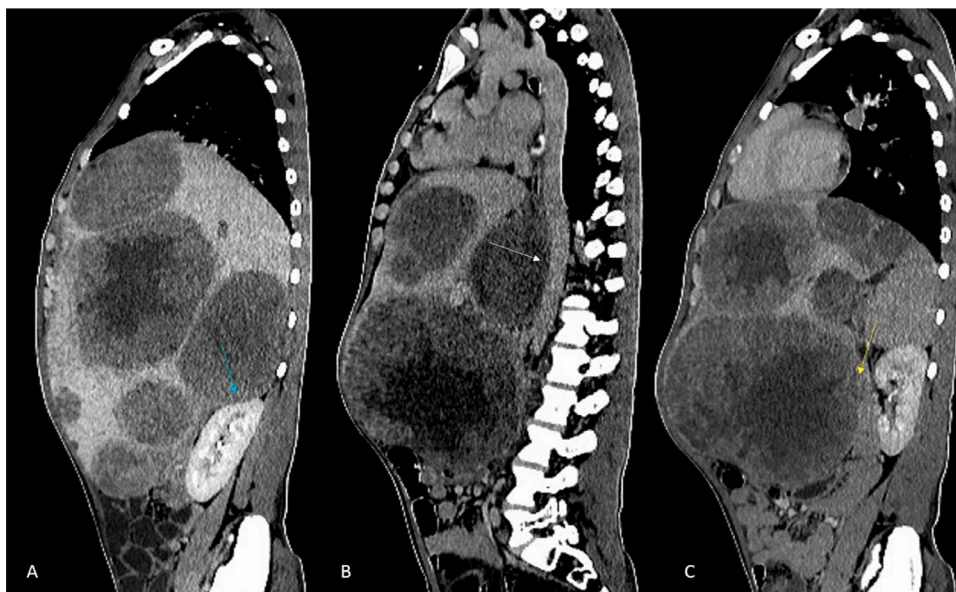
Hepatic epithelioid hemangioendothelioma: contrast enhanced CT sagittal showing multiple heterogeneously hypodense lesions with areas of hypodensity within (A) abutting the right kidney with maintained fat plane (blue arrow), (B) the lesion is in contact with the descending abdominal aorta (white arrow), (C) the left kidney is away from the lesion (yellow arrow).
